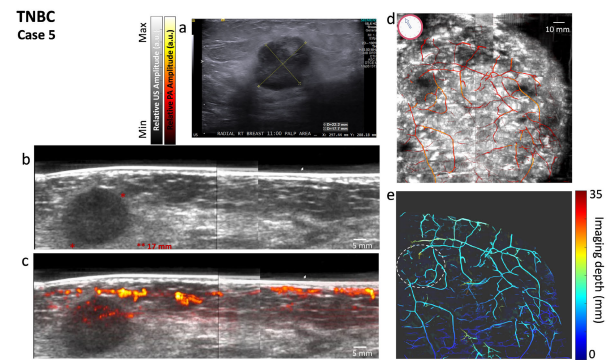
OneTouch-PAT imaging result of a TNBC case. a represents the clinical ultrasound image. b represents the one-touch ultrasound (gray) image. c represents the photoacoustic (color) image overlaid on top of the US image. d represents the 3D projection PA overlaid on top of the US image (frontal view of the breast). e represents the depth-encoded 3D projection PA image (frontal view of the breast).
